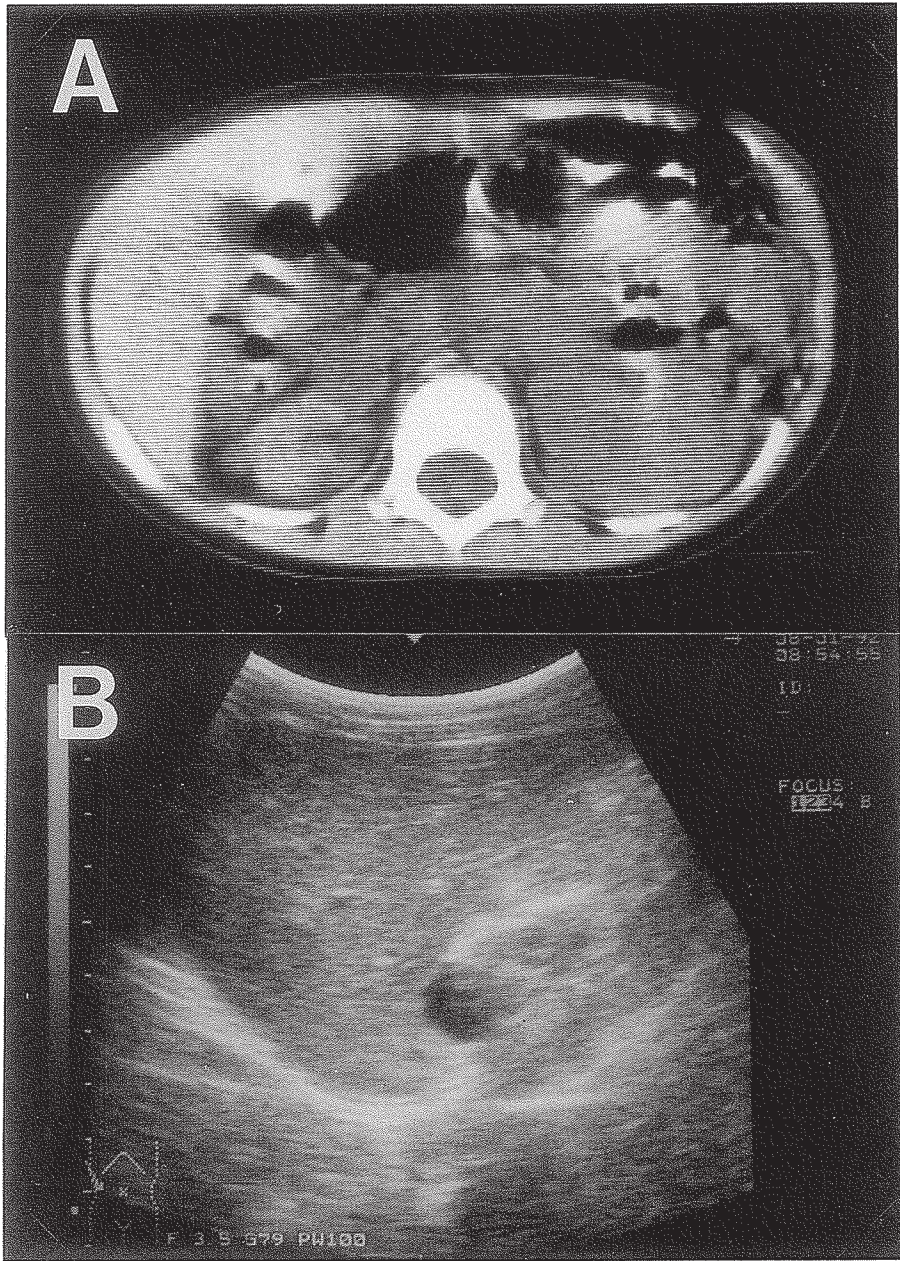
Computed tomography two months after drainage (A) and ultrasonography four months later (B) show nearly undetectable cysts.
